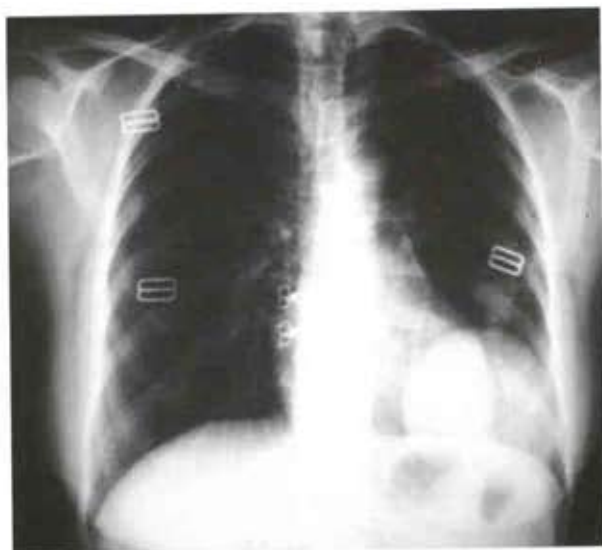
chest radiograph showing a round opacity in left lower lung (hydatid cyst before
